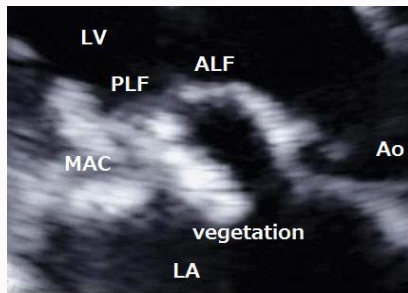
Echocardiography at second admission; Vegetation arose from mitral annulus, and mitral annular calcification appeared swollen as the "puffed-up" description of Eisher et al. [1].
